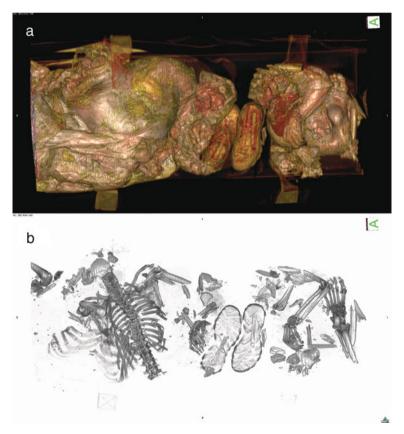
Volume reconstructions of a CT scan of a train suicide victim (Osirix, Osirix foundation, Switzerland). (a) Surface reconstruction. (b) Bone reconstruction for quick assessment of the completeness of the body
